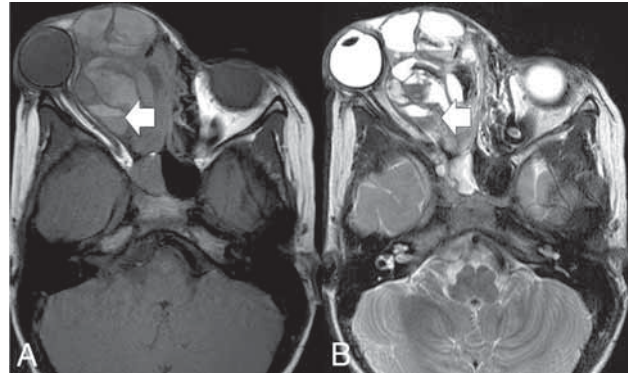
GCG of the orbit with secondary ABC changes appearing as a multiloculated lesion with multiple fluid-fluid levels (*arrow*) of differential signal intensity on T1-weighted (A) and T2-weighted (B) axial images.
